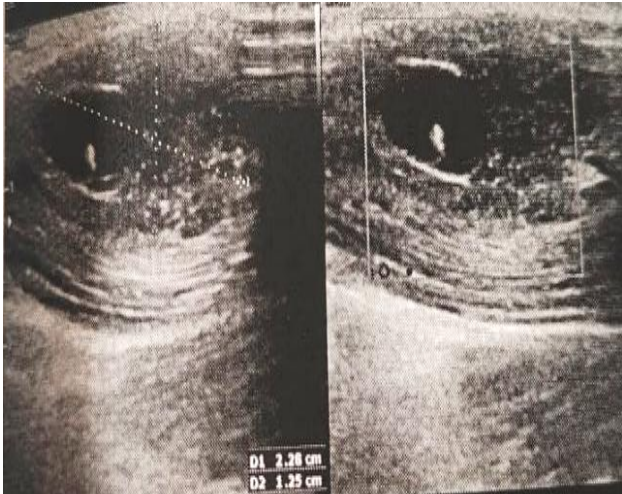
Ultrasonography of neck showing cystic lesion with hyperechoic intra-cystic foci.
